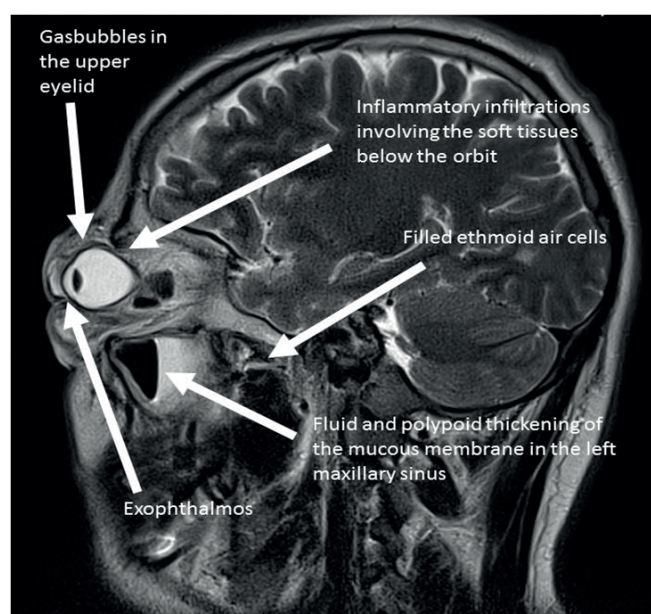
Preoperative nuclear magnetic resonance image of a patient
